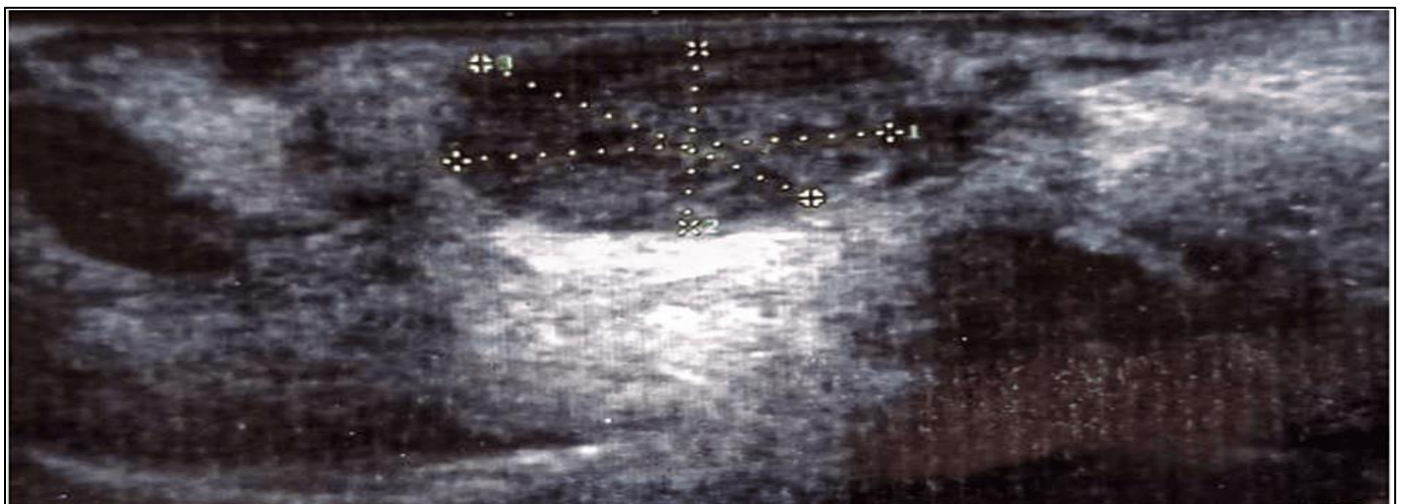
Ultrasonography Image
